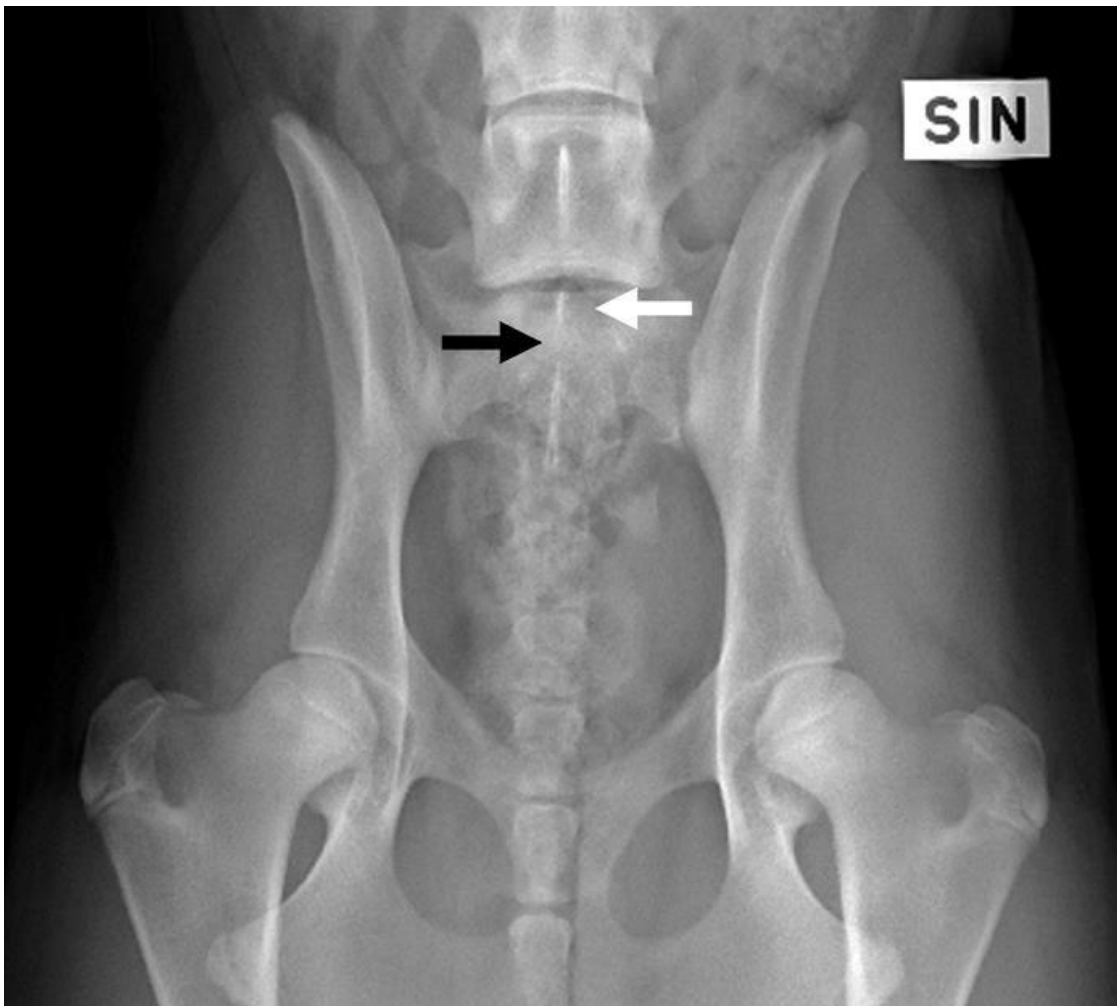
A depression in the median crest between S1 and S2 (LTV1) is seen in radiographs as a separation (black arrow) of the spinous processes of S1 and S2. The spinous process of the S1 is marked with a white arrow.
